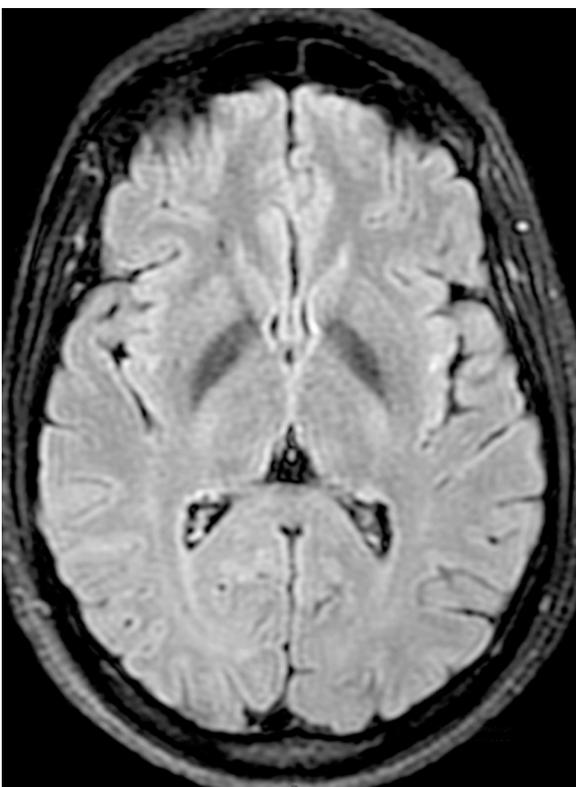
Bilateral insular white matter FLAIR hypersignals in patient-case 12.
